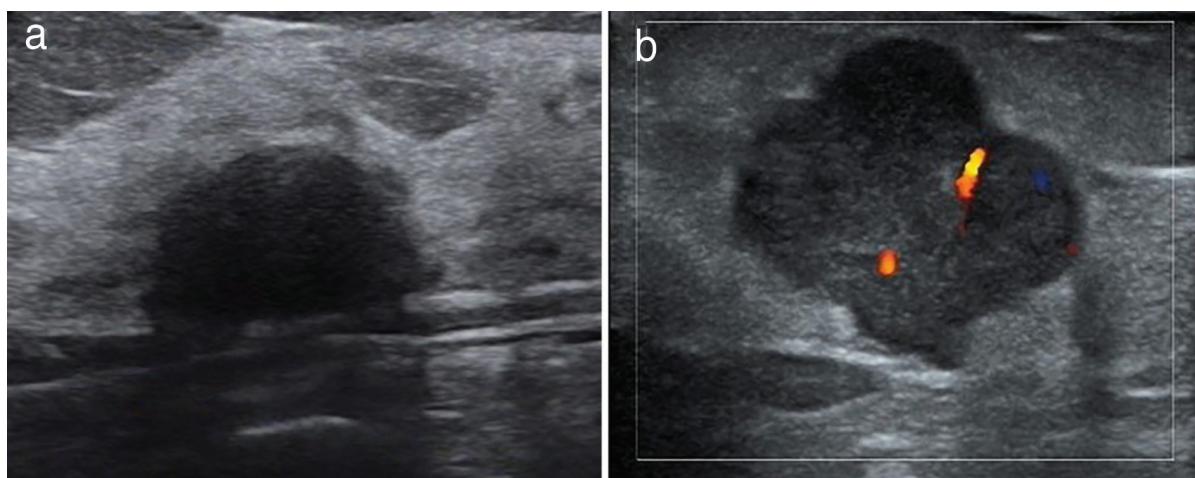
Representative US images of HER2-positive breast cancer (BC). (a) BC lesion with regular shape, parallel orientation, and attenuated posterior echo. Puncture pathology confirmed a CD8⁺-TIL level of 21% (CD8⁺-TIL_{low}). (b) BC lesion with irregular shape, non-parallel orientation, and accentuated posterior echo on ultrasound. Biopsy results confirmed a CD8⁺-TIL level of 65% (CD8⁺-TIL_{high}).
